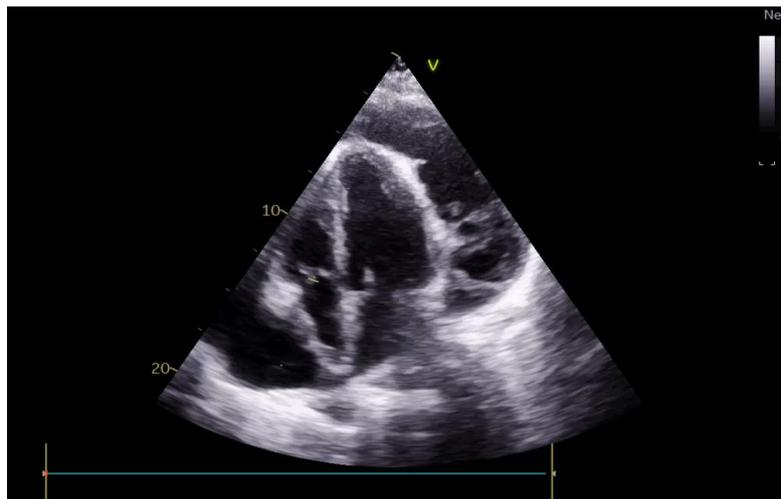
Apical 4-chamber echocardiographic image showing significant pericardial effusion with fibrin deposition
